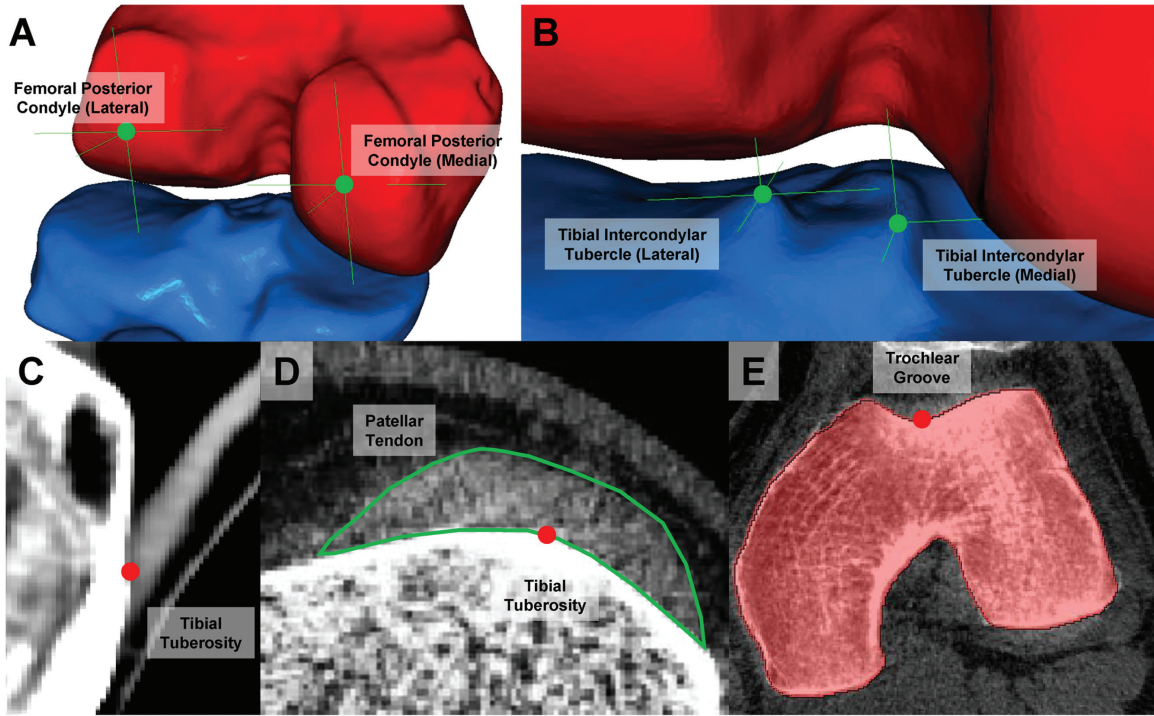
Landmarks (indicated by green and red dots) used in this study. (A) The femoral posterior condylar landmarks were placed at the most posterior point on the medial and lateral condyles. (B) The tibial intercondylar tubercle landmarks were placed on the tibial plateau’s most prominent medial and lateral features. The tibial tuberosity landmark was placed using sagittal and axial slices of the computed tomography scan. (C) The sagittal slice was used to determine the superoinferior position. (D) Afterward, the landmark was moved medially or laterally on the axial view to be placed precisely within the middle of the patellar tendon (outlined in green on the axial slice). (E) The trochlear groove landmark was placed in the deepest part of the trochlear groove.
